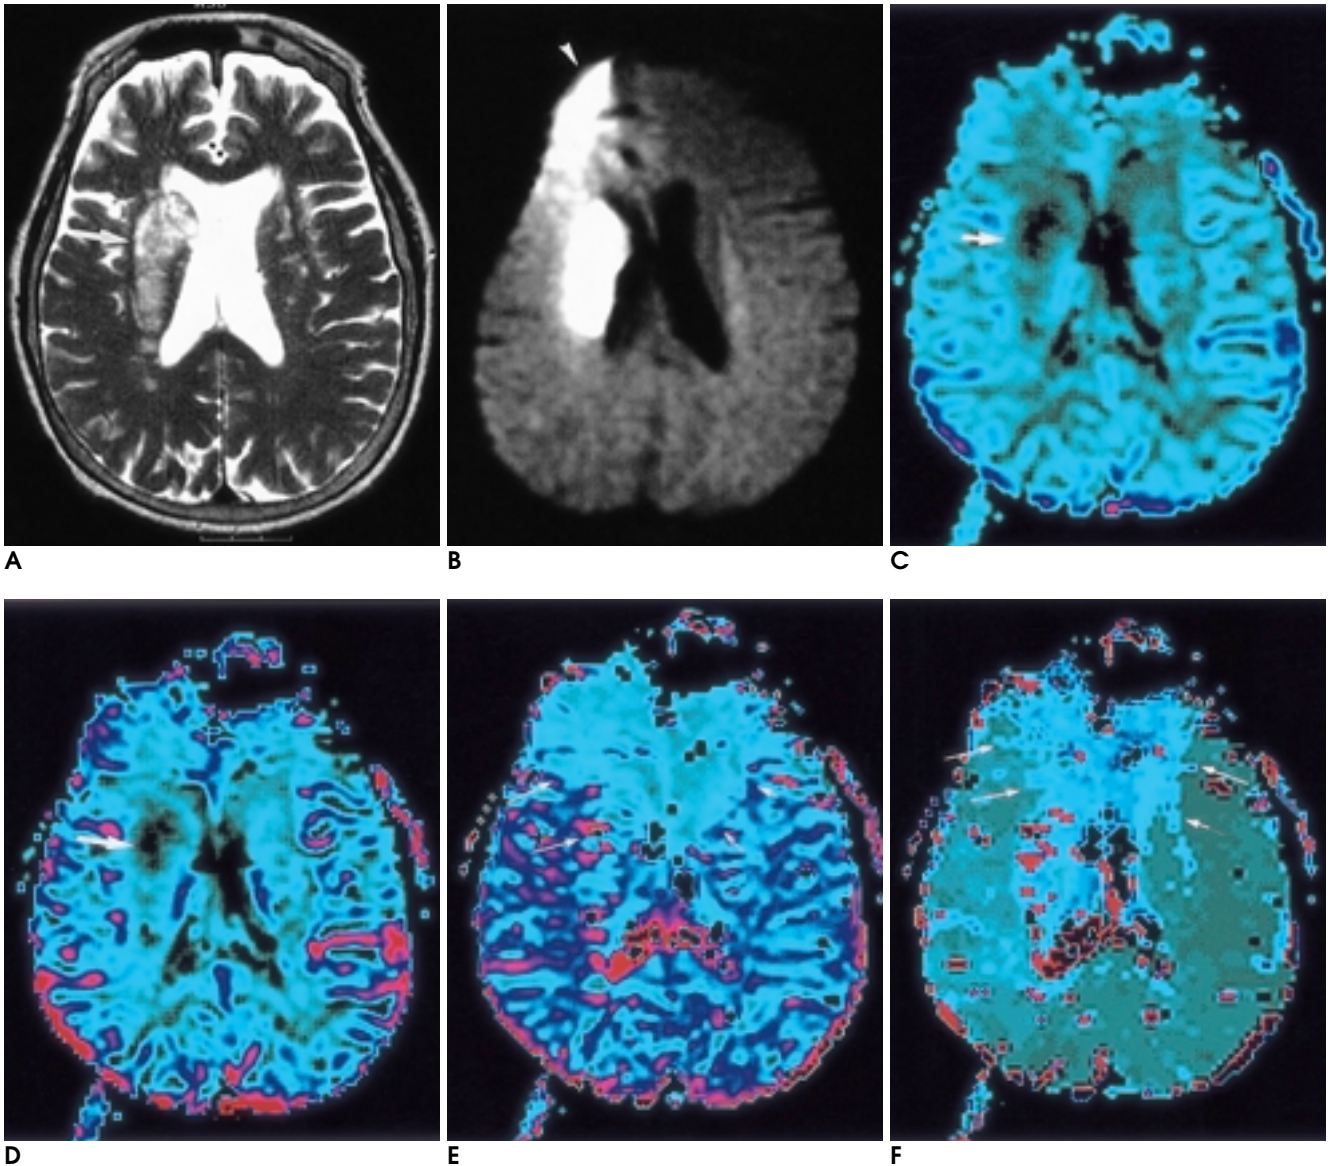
A 76-year old woman with acute infarction. MR images were obtained 4 days after symptom onset.
